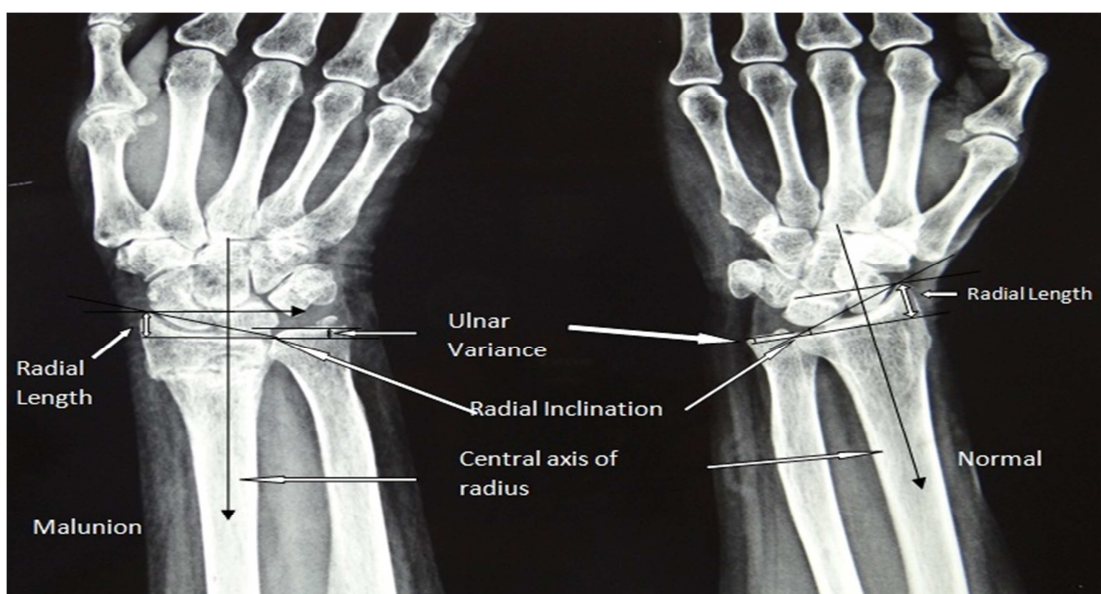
Radiograph of patient hands with wrist (PA view).
